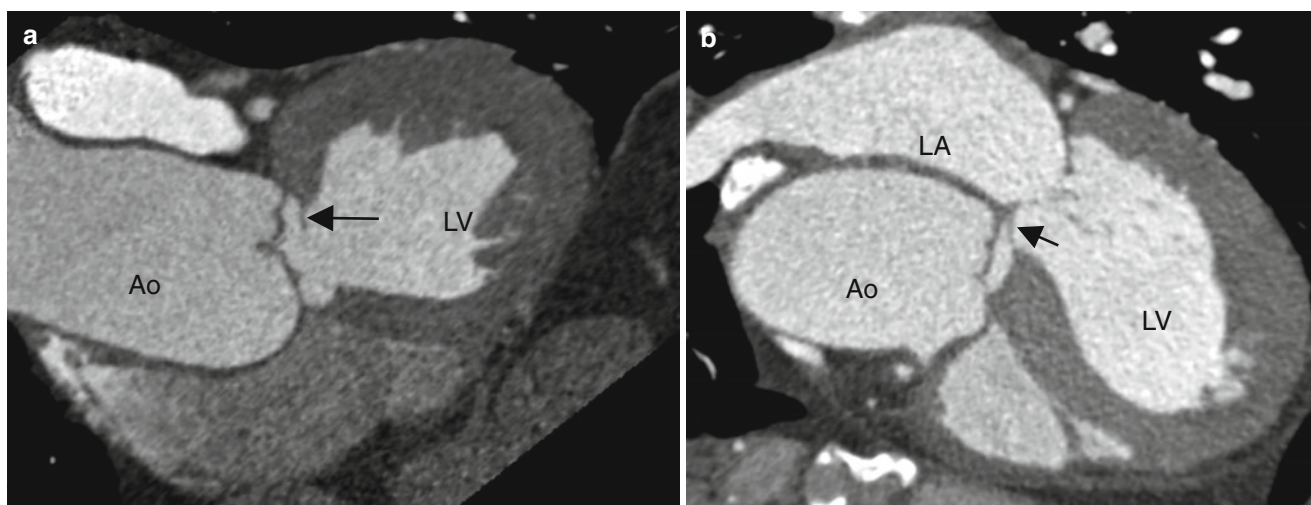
Short-segment subaortic stenosis in a 65-year-old male, who initially was diagnosed with hypertrophic cardiomyopathy with left ventricular outflow tract obstruction. Panels (a) and (b) are two reformatted CT scans showing a subaortic membrane (arrow) extending to
